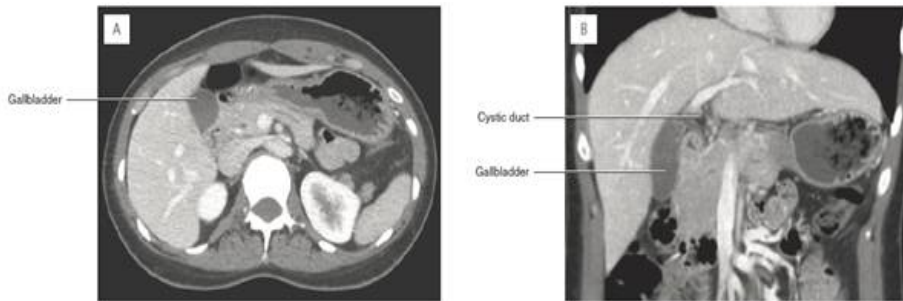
The appearance of the gallbladder on CT. (A) Axial and (B) coronal CT images.
